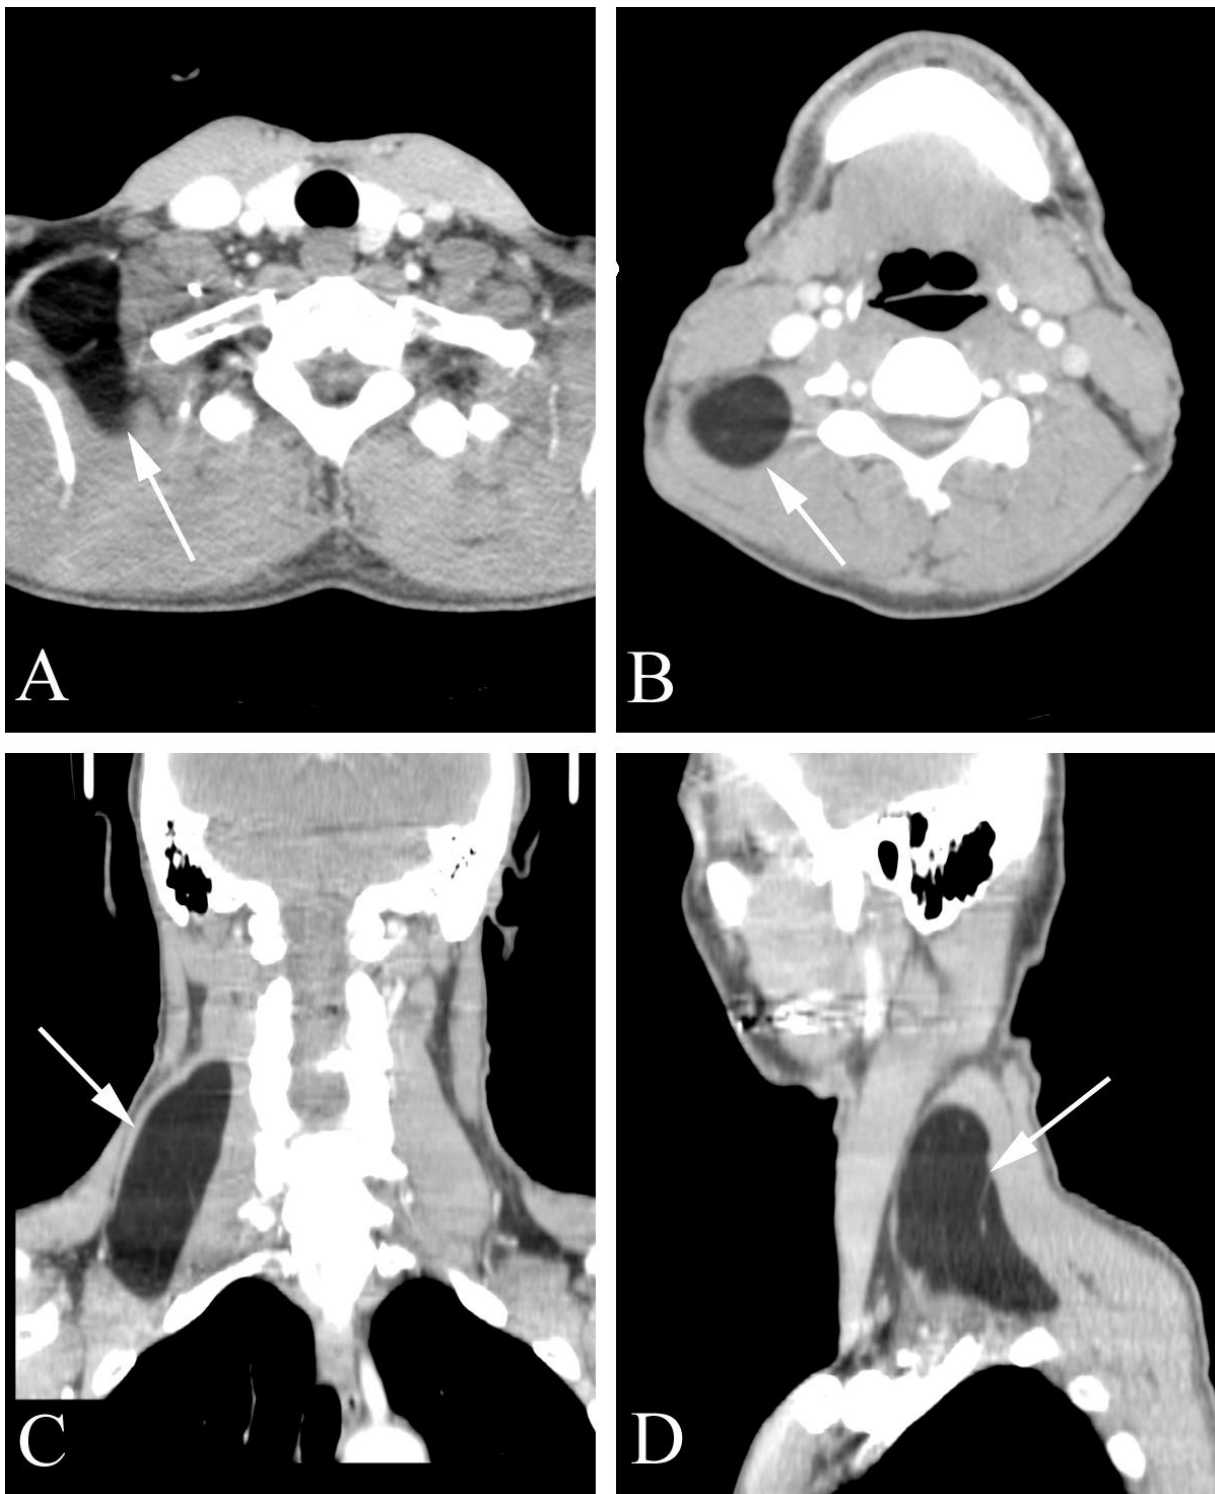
Benign lipoma in a 62 year old man with a palpable neck mass. A. Axial contrast-enhanced CT at the level of the thyroid gland shows a triangular soft tissue mass of fat density (arrow) in the right neck. B. Axial contrast-enhanced CT at the level of the aryepiglottic folds shows extension of the mass (arrows) superiorly, where it lies behind the sternocleidomastoid muscle (which is rotated slightly compared to the contralateral, normal side). C. Coronal reformatted contrast-enhanced CT study shows the lipoma (arrow) along the right neck, lateral to the spine. D. Sagittal reformatted contrast-enhanced CT shows the lipoma (arrow) posterior to the sternocleidomastoid muscle.
